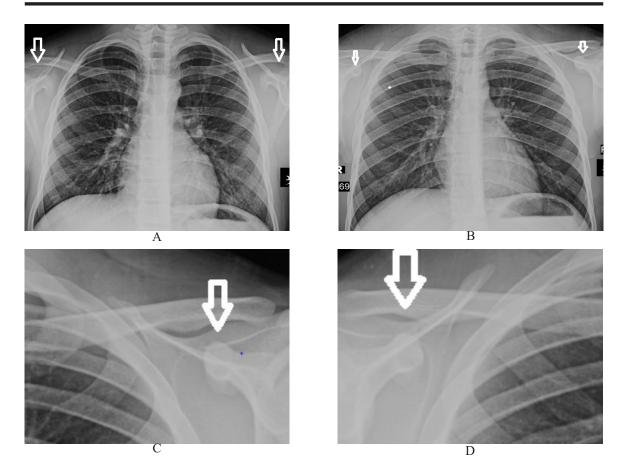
(A): Normal chest X-ray in one patient did not show the CCJ, (B): chest X-ray showing the CCJ bilaterally, (C): coned view on left CCJ & (D): coned view on right CCJ.
